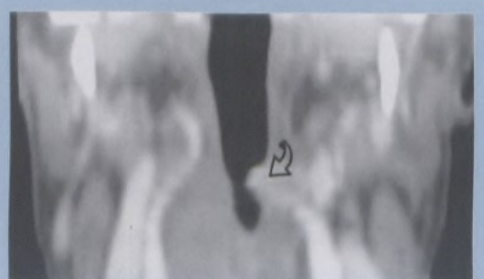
MPVR coronal CT image shows the soft tissue mass projecting into the hypopharyngeal airspace on the left (open arrow).
